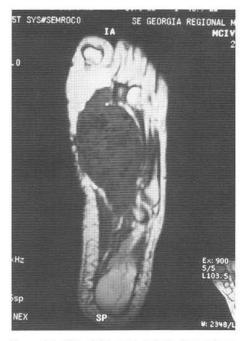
MRI of the same patient. A very large plantar mass with obliteration of much of the intrinsic musculature, but still confined to the plantar vault. Previous incisional biopsy revealed a diagnosis of leiomyoma.
